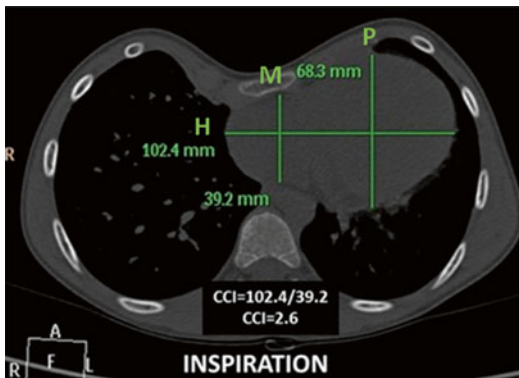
Calculation of the Cardiac Compression Index (CCI) and the Cardiac Asymmetry Index (CAI) from a Chest CT at end-inspiration. $CCI=102.4/39.2=2.6$ (Cut-off point: 1.82); $CAI=68.3/39.2=1.74$ (Cut-off point 1.15)
